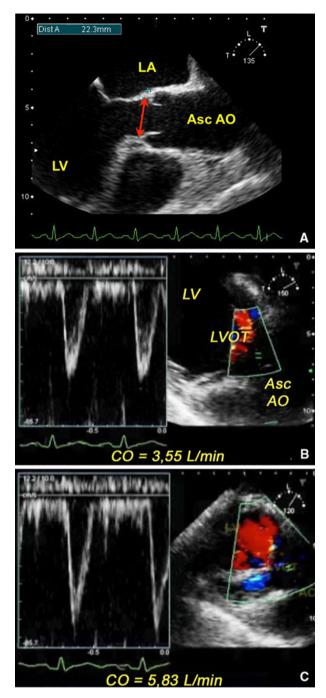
TEE Doppler assessment of cardiac output in a community-acquired pneumonia patient with septic shock (same patient of Fig. 5). Patient is hypotensive and badly perfused and 2D images show a pattern of biventricular dysfunction. LVOT diameter is measured in a midesophageal long axis view (a, *red double-headed arrow*) and LVOT cross sectional area calculated (LVOT diameter = 2.23 cm; CSA = 1.115 cm \times 1.115 cm \times 3.14 = 3.90 cm²). Measured LVOT VTI (panel 3B, TEE transgastric long axis view) is 8.7 cm, calculated stroke volume is 34 ml (3.90 cm² \times 8.7 cm), and heart rate 104 bpm, yielding a CO of 3.55 L/min. Epinephrine infusion [0.01 mcg/(kg min)] restores adequate pressures and flows, increasing LVOT VTI to 12.7 cm, SV to 49 ml (3.90 cm² \times 12.7 cm), heart rate to 120 bpm and CO to 5.83 L/min (c). *LVOT* left ventricular outflow tract, *VTI* Doppler velocity—time integral, *CO* cardiac output
